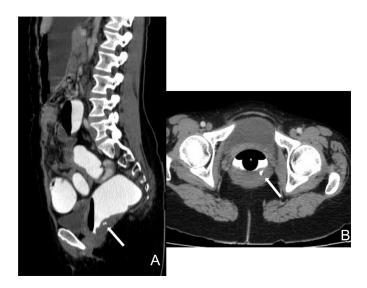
CT-Scan: Sagittal (A) and Axial (B) sections with gastrografin opacification showed a posterior rectal mass containing phleboliths.
